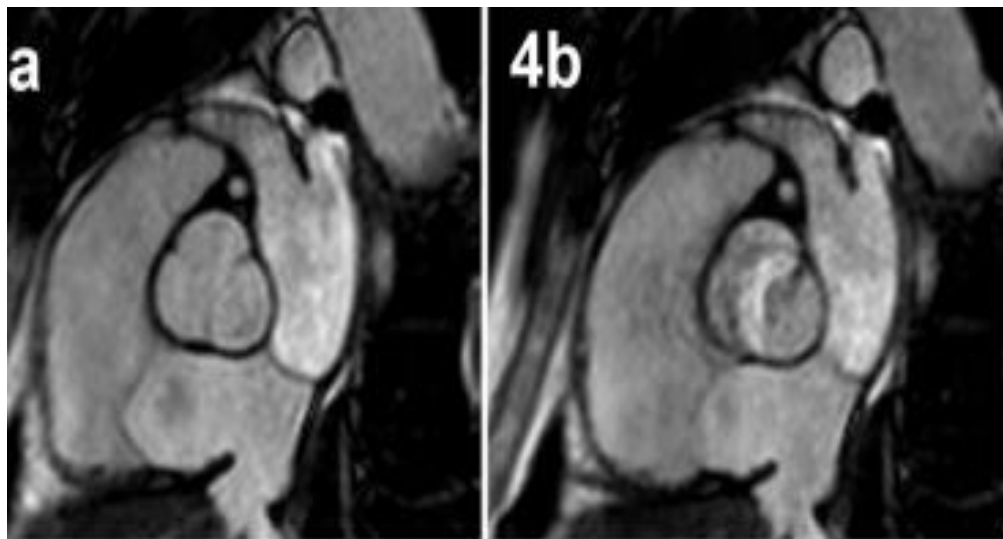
Cardiac magnetic resonance imaging of a bicuspid aortic valve in diastole (A) and systole (B). Turbulence through the aortic valve is seen as white (21).
